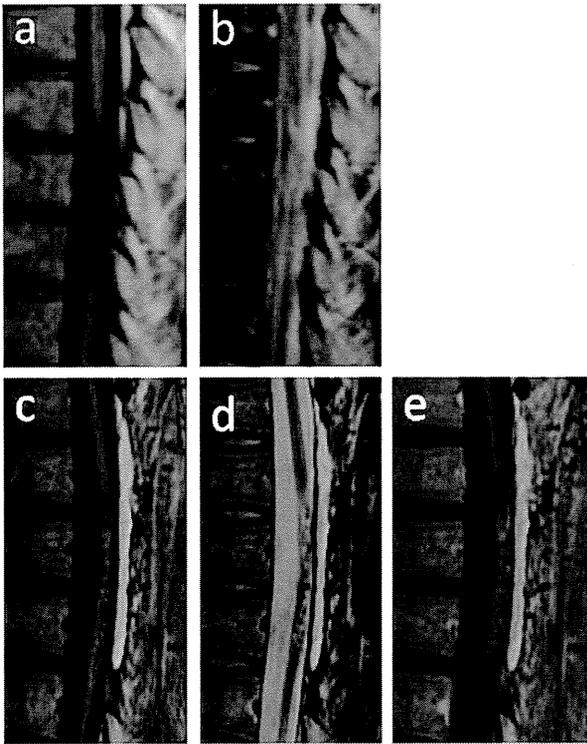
MRI findings in case 2. T1-weighted sagittal image before transplantation showed atrophic change of the thoracic spinal cord (a); T2-weighted sagittal image before transplantation showed an intramedullary high-intensity area (b); MRI scans at 48 weeks after transplantation showed fairly complete filling of cavities and heterogeneous intensity on T1- (c) and T2-weighted images (d); Gd-enhanced MRI showed that the grafts were enhanced heterogeneously (e). No evidence of neoplastic tissue overgrowth was observed.
